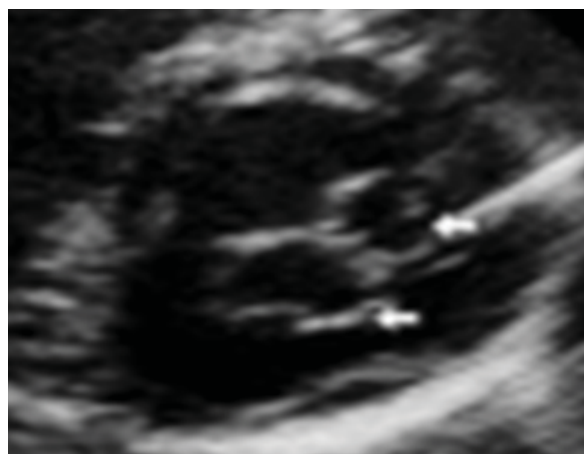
Apical two chamber view showed a small tissue like structure dividing the common mitral annulus into two
